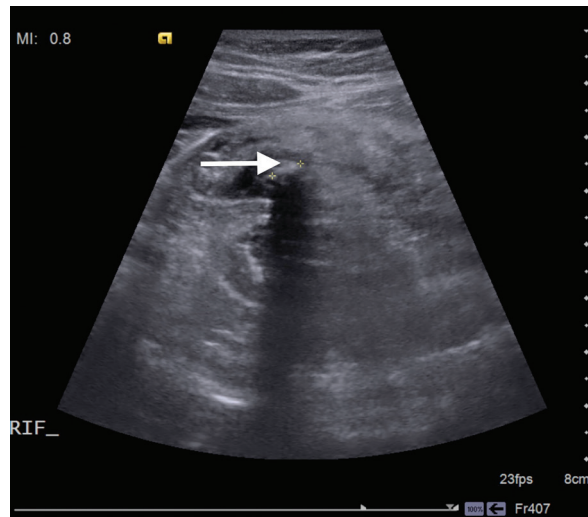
High resolution ultrasound demonstrating an appendicolith (arrowed) as an echogenic structure with acoustic shadowing, within the lumen of the appendix.
